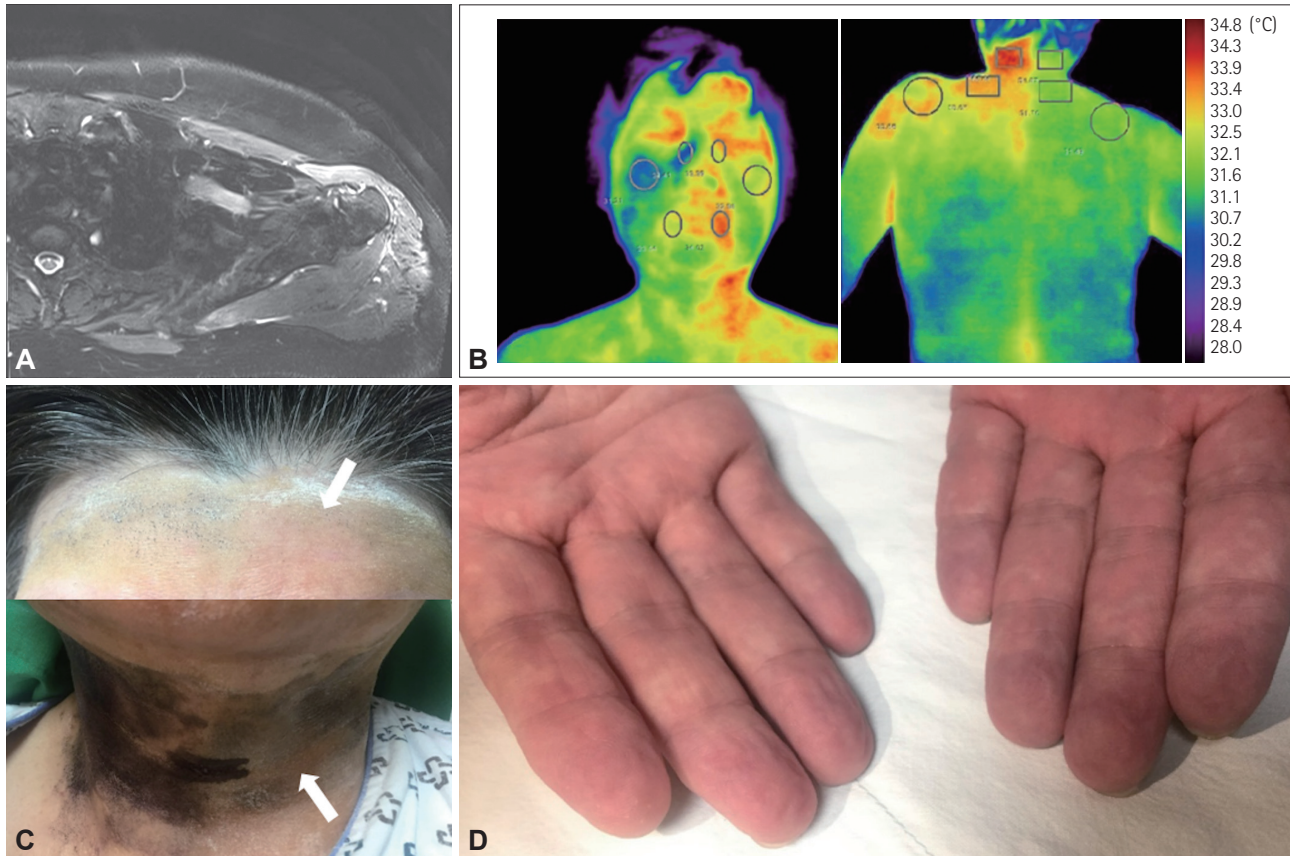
Imaging and clinical findings of the patient. A: Shoulder MRI showed slight signal changes in the deltoid, pectoralis major, and infraspinatus muscles. B: Digital infrared thermal imaging showed that the temperature was lower on the right side of the face and shoulder than on the left. C: The starch test revealed anhidrosis on the left forehead and neck (arrows), while it showed color changes by sweating on the right. D: The finger wrinkle test involving warm water immersion produced skin wrinkles on the right fingers but not the left fingers.
